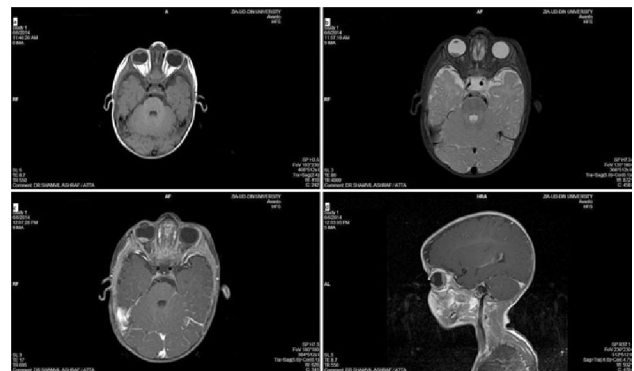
MRI images of orbit including brain of 7 months old male child showing retinoblastoma in right globe. a. T1W axial b. T2W axial c & d. T1W post gadolinium axial and sagittal images. It is showing isointense endophytic plaque like mass on T1W which appear hypointense to vitreous on T2W. The lesion shows homogenous significant post contrast enhancement. Both optic nerves appear normal. Bilateral ethmoid sinusitis is incidentally noted.
